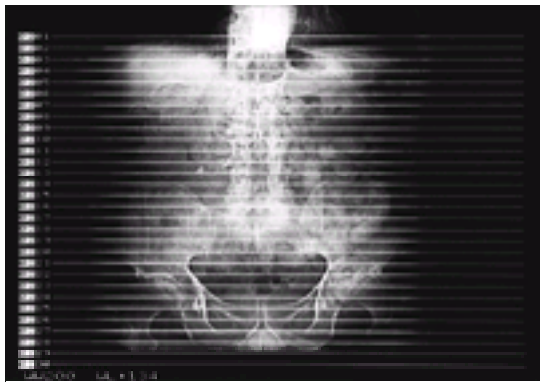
Digital radiograph obtained at the start of the examination, showing the area to be examined. This examination records 30 sections, taken from the dome of the diaphragm to the pelvic floor.
